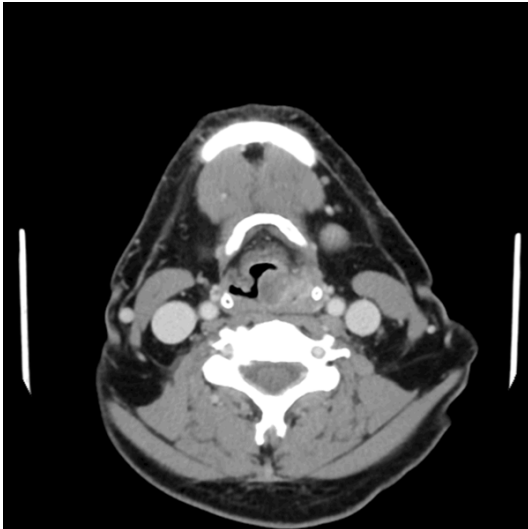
Enhanced CT scan (venous phase) showed a nodule protruding into the laryngeal cavity.
